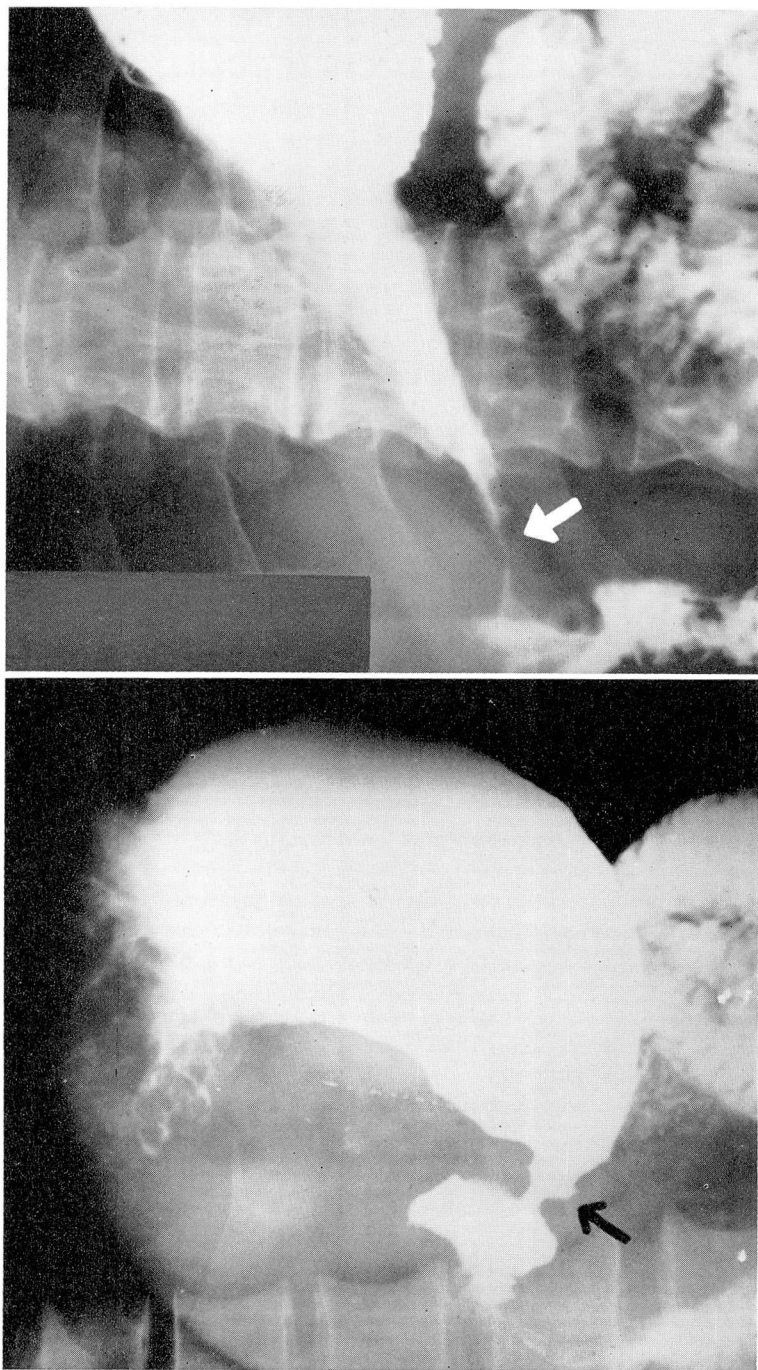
(A) Preoperative roentgenogram of stomach, (B) showing prepyloric narrowing.
